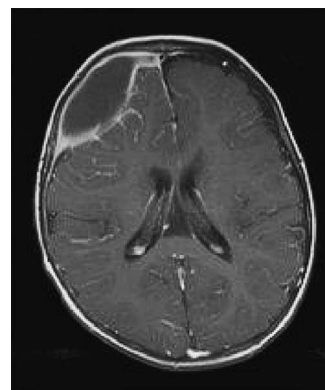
T<sub>1</sub> weighted magnetic resonance imaging (MRI) with gadolinium enhancement before first operation.
